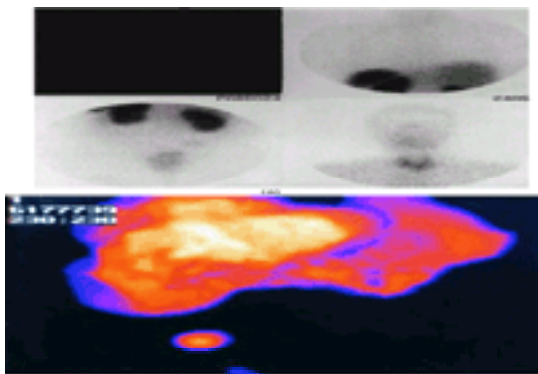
(a) Planar indium-111 octreotide scintigram showing the normal distribution of the radiopharmaceutical in the kidneys, bladder, thyroid, pituitary, liver, and spleen. The presence of renal images covering a large area of the abdomen is a disadvantage compared with iodine-123 MIBG. (b) Three-dimensional images constructed from SPET cross-sections following indium-111 octreotide, showing a carcinoid tumour in the appendix.
